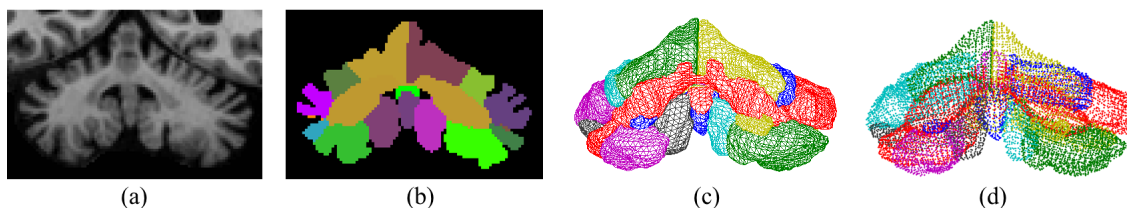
From MR image to lobule meshes: a) MR image of the cerebellum; b) Lobule segmentation; c) Triangular meshes of all lobules; d) Vertices of the lobule meshes.
